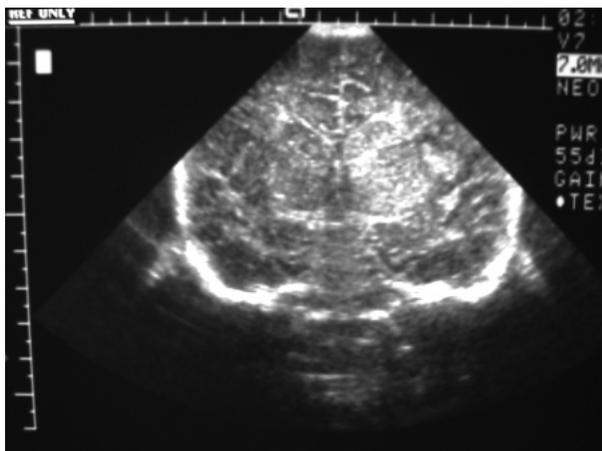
Ultrasonogram of the infant's head demonstrating increased echogenicity in the left basal ganglia and thalamus.
